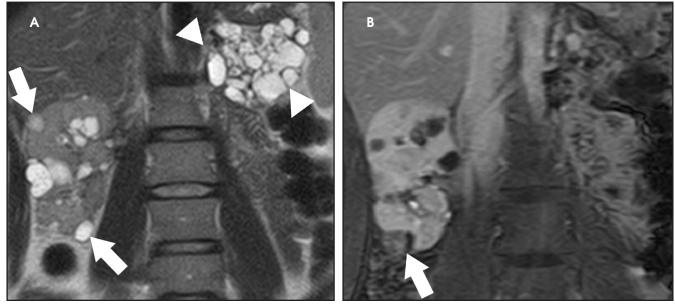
A 24-year-old woman with von Hippel-Lindau disease. Coronal T2- weighted (A) and gadolinium-enhanced (B) MR images show multiple simple and complex cysts and enhancing masses (arrows) in the right kidney. Also note multiple cysts in the pancreas (arrowheads). This patient is status post-left nephrectomy as she had multiple renal carcinomas in the left kidney.
